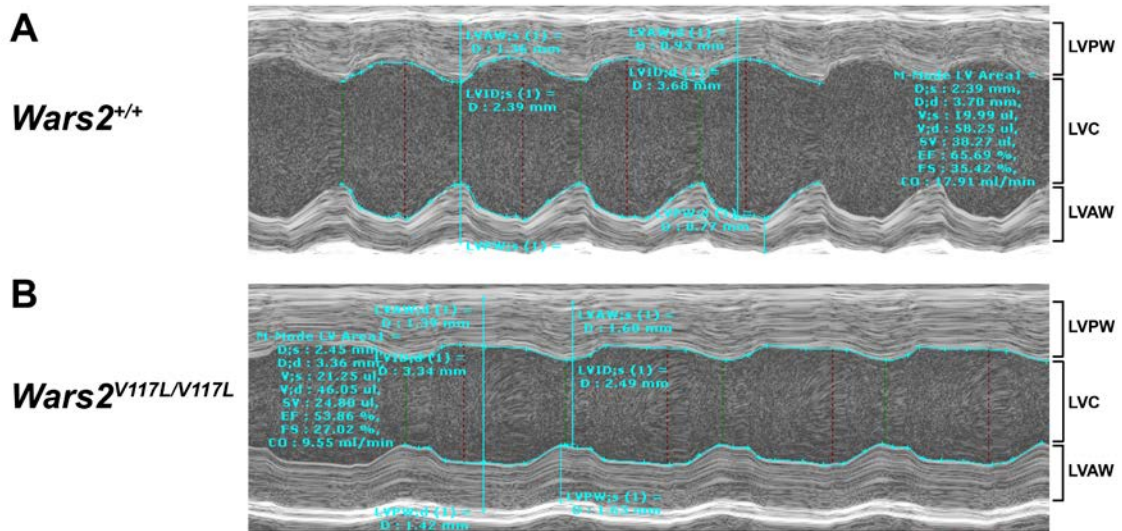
Representative analysis of *Wars2^{V117L/V117L}* Echocardiogram images in M-mode.
